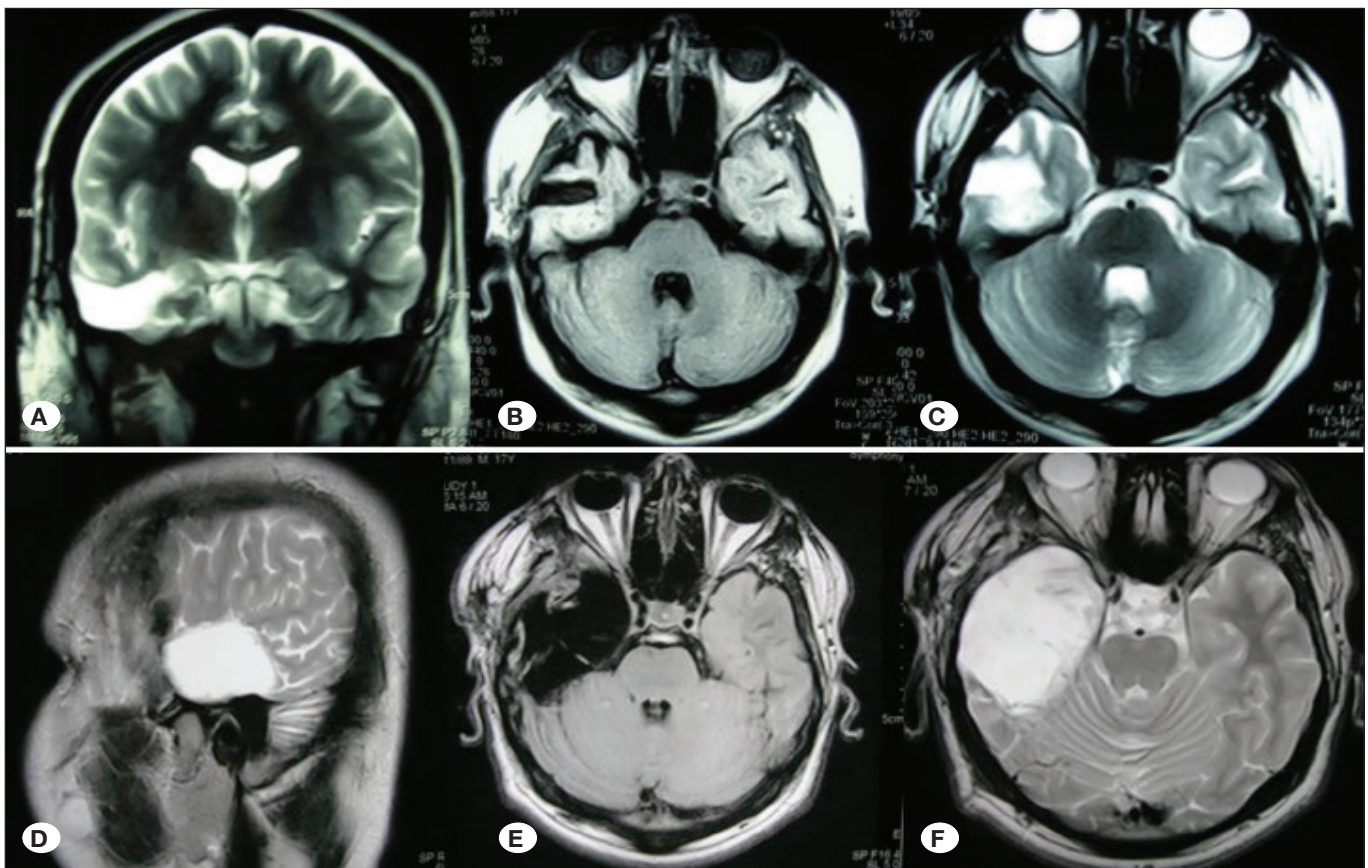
A-C) Preoperative brain magnetic resonance imaging (MRI) sections of patient #2; D-F) brain MRIs (D: T2W coronal, E: T1W axial, F: T2W axial) after the second surgical treatment of the patient.
